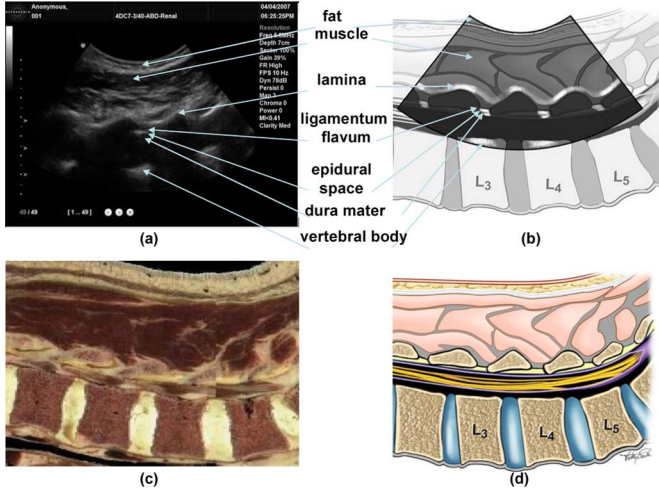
(a) Ultrasound image of paramedian plane of the lumbar anatomy. (b) Idealized ultrasound image of the anatomy. (c) Slice through the Visible Human [10] at the location of the lumbar anatomy. (d) Pictorial view of the corresponding lumbar anatomy.
